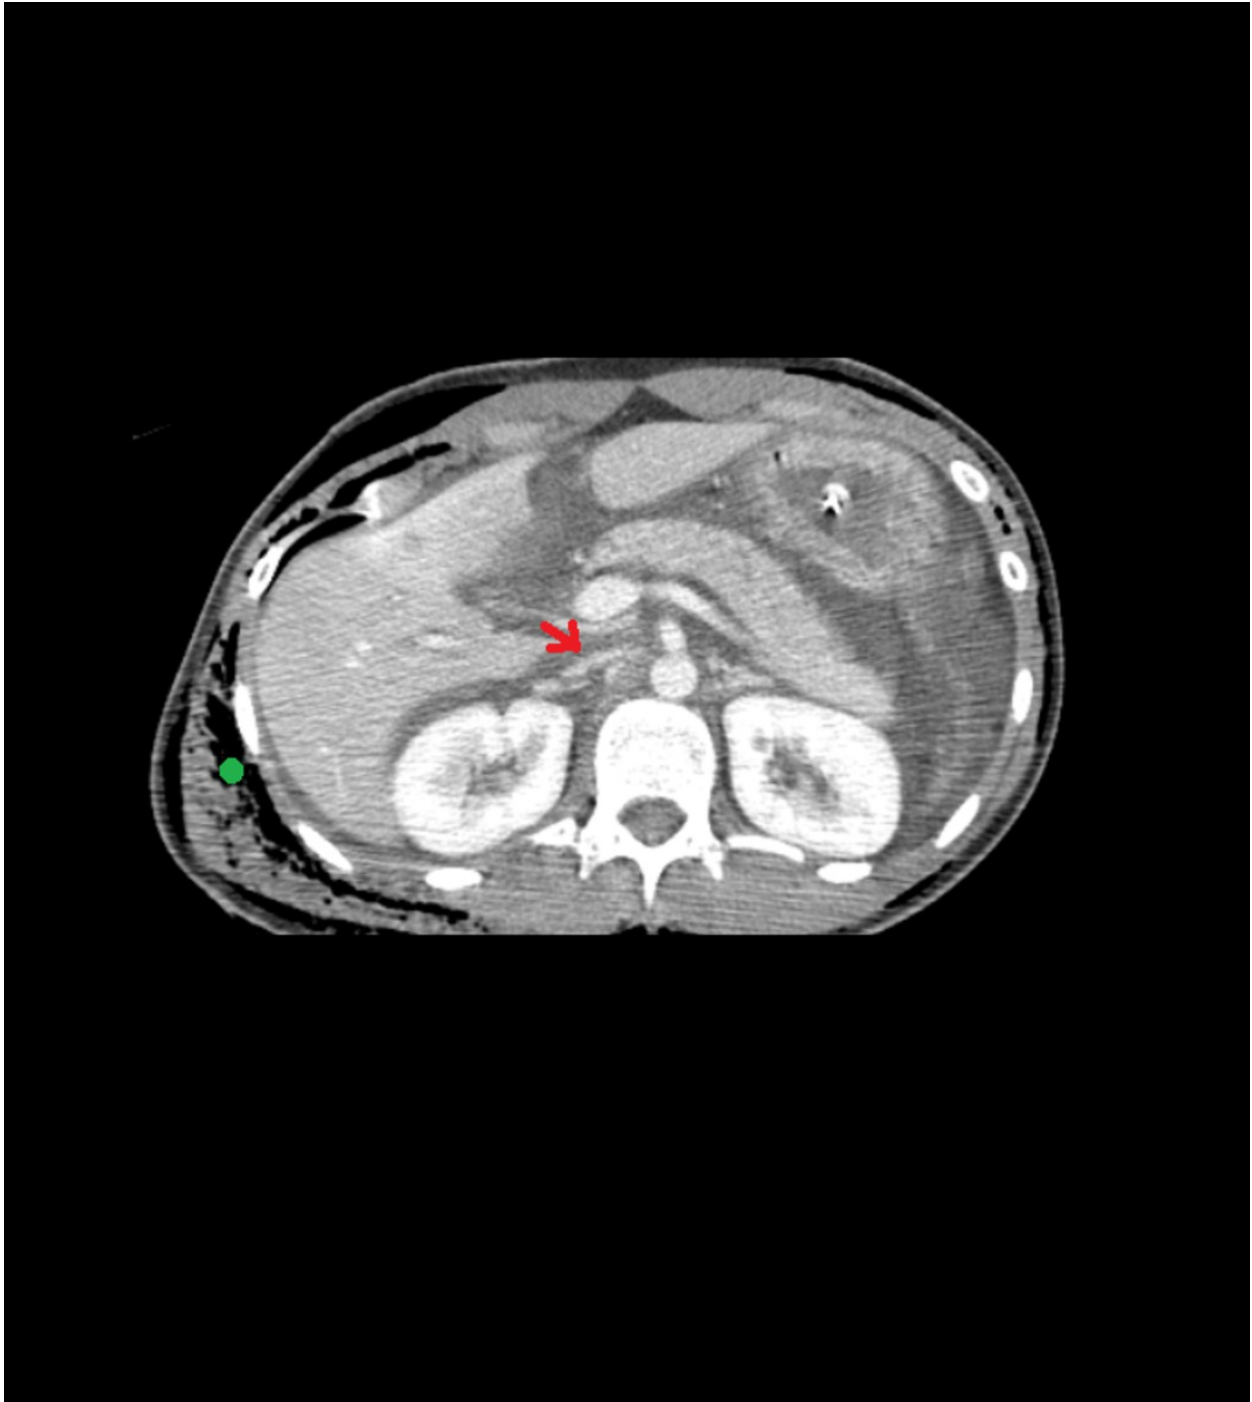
Flat IVC in a 25-year-old woman who had been involved in a traffic accident. Contrast-enhanced CT scan reveals a collapsed IVC (red arrow). Note also subcutaneous emphysema (green dot).
